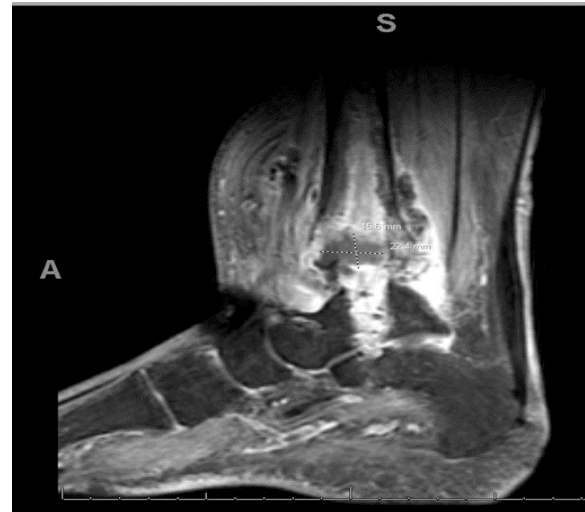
MRI of left ankle.
